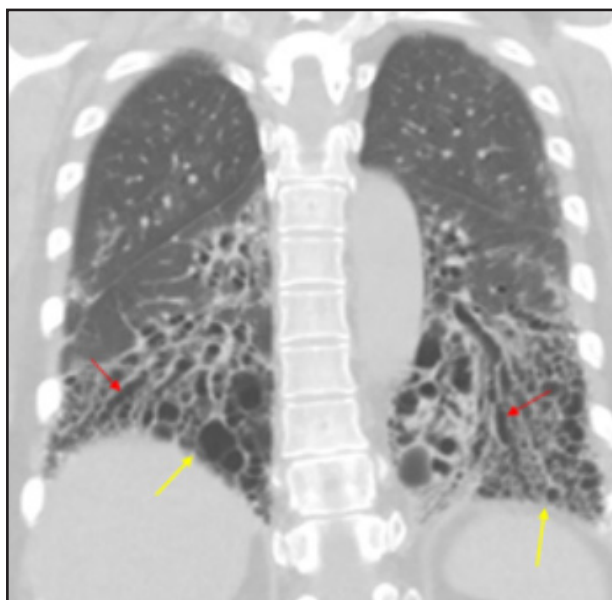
Idiopathic pulmonary fibrosis. Coronal contrast-enhanced CT image demonstrating a UIP pattern of subpleural and basilar predominant honeycombing (yellow arrows) with traction bronchiectasis (red arrows).
